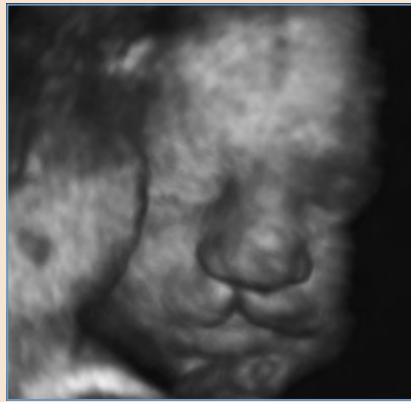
Three-dimensional ultrasound image of a fetus with a right cleft lip.
